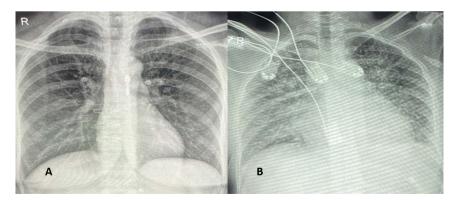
Chest X-rays of the patient on admission (A), and on her ICU admission (B) with non-cardiogenic pulmonary edema.
